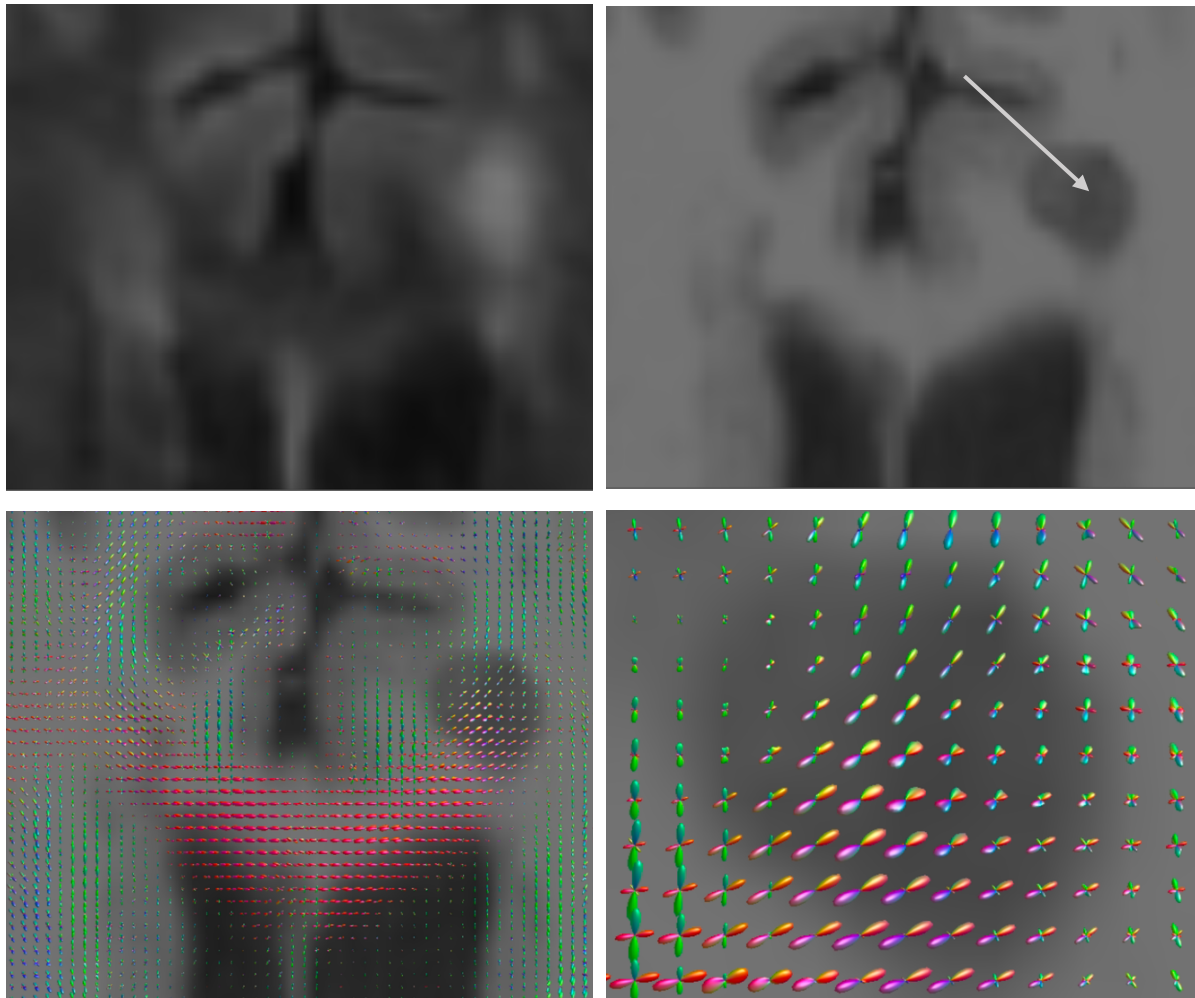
MS lesion in the left frontal lobe adjacent to the genu of the corpus callosum; Top left FLAIR T2 hyperintensity; Top right T1 hypointensity; Bottom left T1 overlaid with FODs; Bottom right close-up of lesion T1 with overlaid FODs. Arrow shows the lower T1 signal in the lateral aspect of the lesion.
